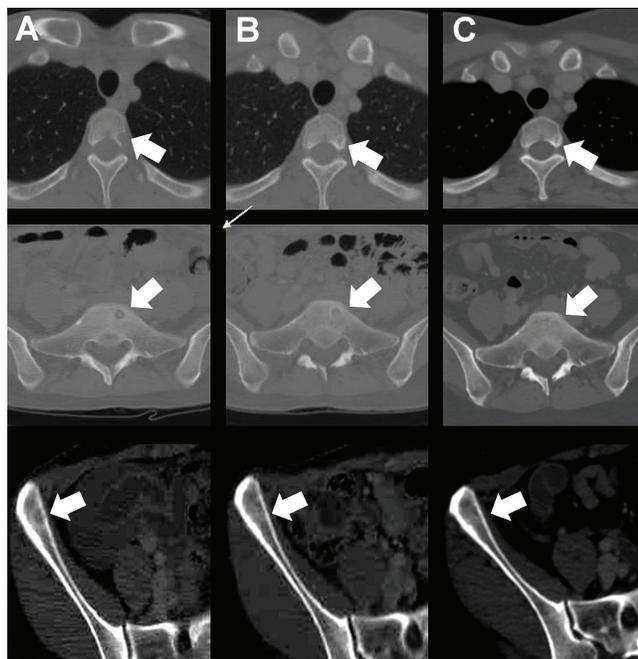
Systemic computed tomography showing the long-term response of bone metastases in T3, sacral bone, and right ilium. (A) Initial admission (baseline). (B) Immediately after 6 courses of chemotherapy. (C) After 7 years of chemotherapy. Low-density areas were ossified from peripheral areas at time B and remained ossified at time C, suggesting that the regimen was effective in treating the metastatic angiosarcoma; the patient experienced 7 years of progression-free survival.
